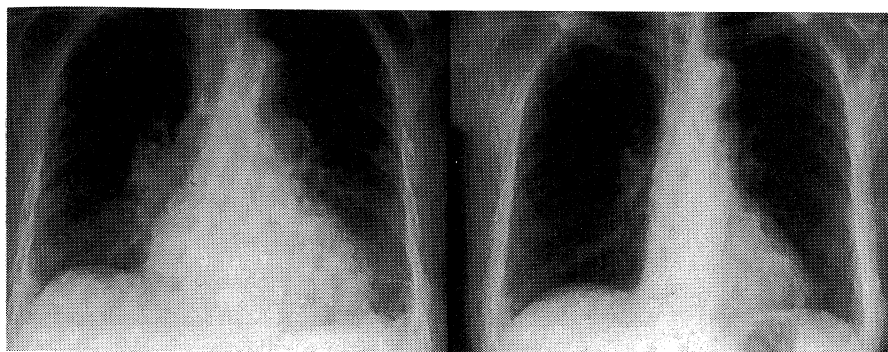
Chest roentgenogram. A | B
